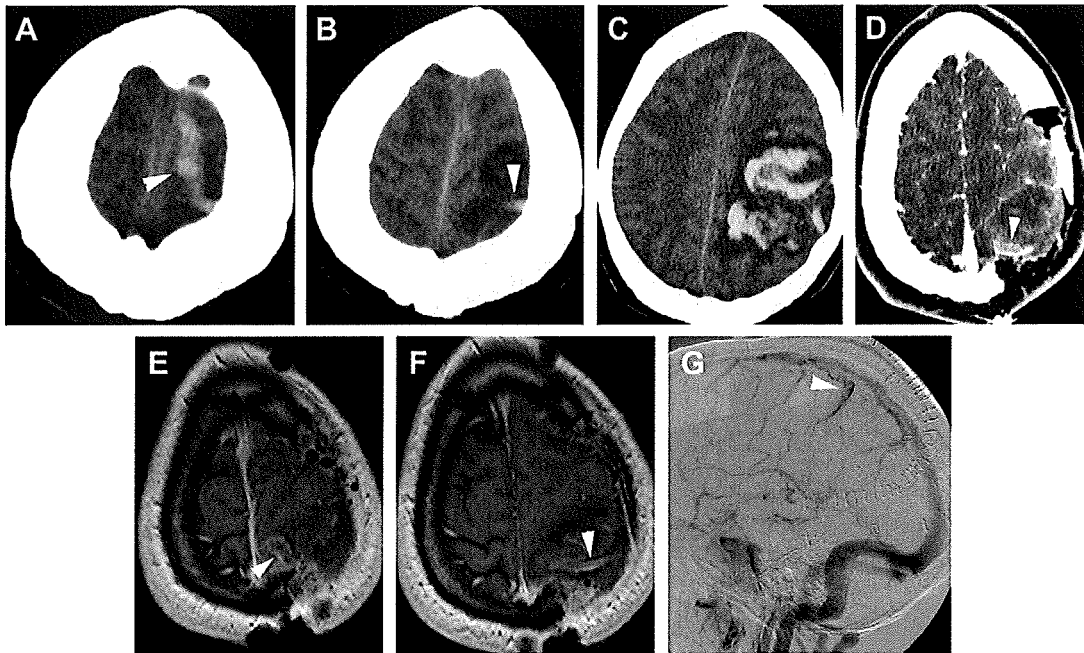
Isolated cortical vein thrombosis. Axial noncontrast CT images (A, B, and C) demonstrate a curvilinear hyperdense structure (*arrowheads*) along the left parietal lobe consistent with a thrombosed cortical vein. A large intraparenchymal hemorrhage with surrounding hypoattenuation consistent with vasogenic edema is seen in the left parietal lobe in image C, compatible with a venous hemorrhagic infarct. Axial CT angiographic image after left parietal craniectomy for decompression (D) shows a filling defect (*arrowhead*) within an enlarged left parietal cortical vein consistent with thrombus. Axial postgadolinium 3D magnetized-prepared rapid gradient echo images after left parietal craniectomy for decompression (E, F) confirm the filling defect (*arrowheads*) in the left parietal cortical vein consistent with thrombus. Lateral view of a catheter angiogram in the venous phase (G) also shows the filling defect in the parietal vein (*arrowhead*), confirming the venous thrombosis.
